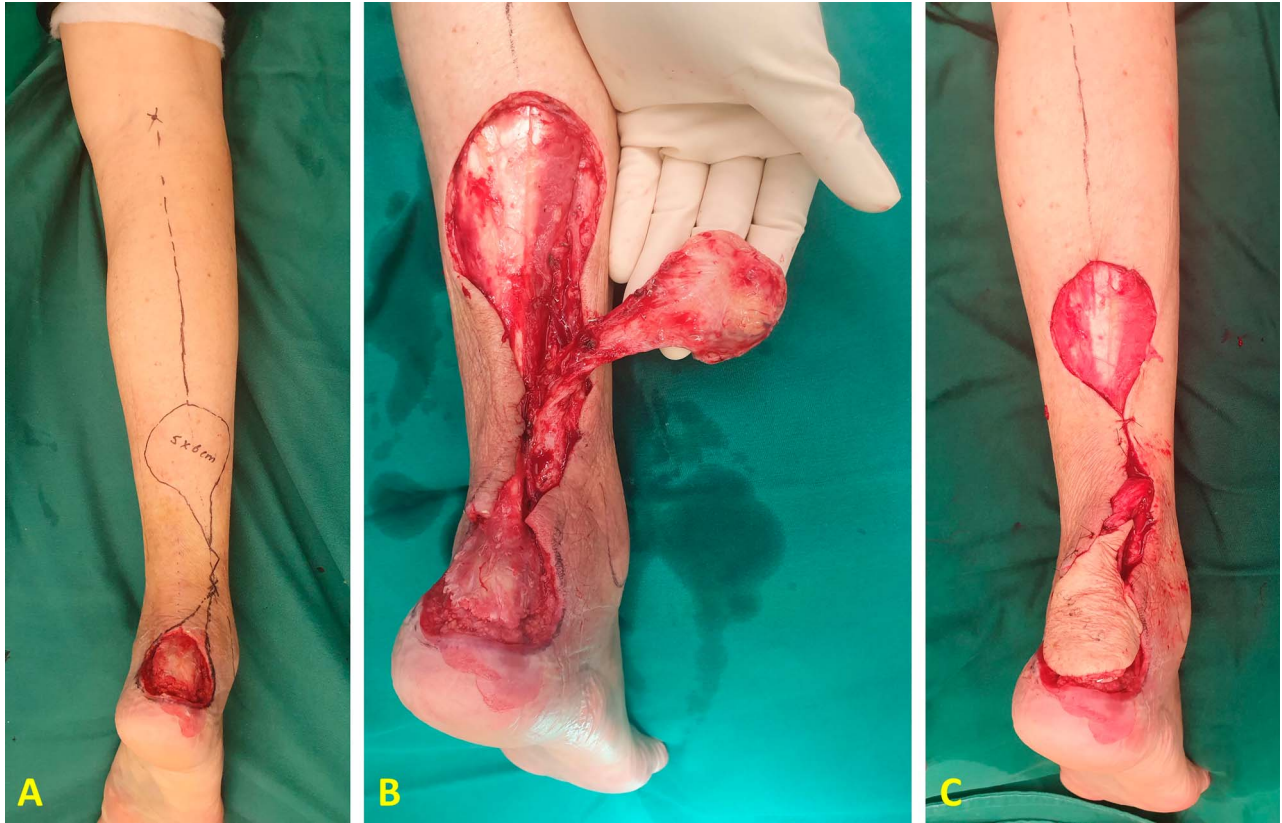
(A) A 71-year old woman with diabetes and ischemic heart disease presented 1 week after sustaining a displaced, open calcaneal fracture. She had avoided medical treatment earlier because of the imposed “lockdown” measures. (B) The fracture was fixed with cannulated screws and a sural fasciocutaneous flap was used to reconstruct the soft-tissue defect. (C) The strategies we use to ensure flap survival are: (1) identifying perforators using bedside Doppler, (2) leaving a generous cuff of tissue around the pedicle, (3) avoiding a subcutaneous tunnel, and (4) delaying inset.
